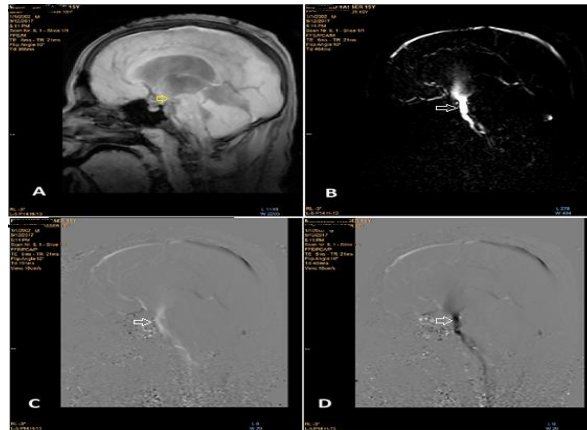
Cine MR images show the qualitative data of CSF flow, (A) Re-phased, (B) magnitude, (C-D) phase images showed bidirectional ETV CSF flow.
